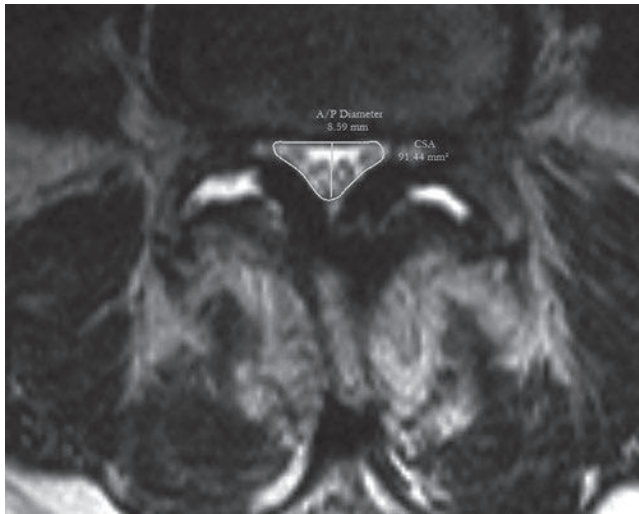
An axial T2-weighted image of the lumbar spine shows the cross-sectional area and AP measurements and depicts a positive sedimentation sign. (From Fazal A, Yoo A, Bendo JA. Does the presence of the nerve root sedimentation sign on MRI correlate with the operative level in patients undergoing posterior lumbar decompression for lumbar stenosis? *Spine J.* 2013;13(8):837–842. Reprinted by permission.)
